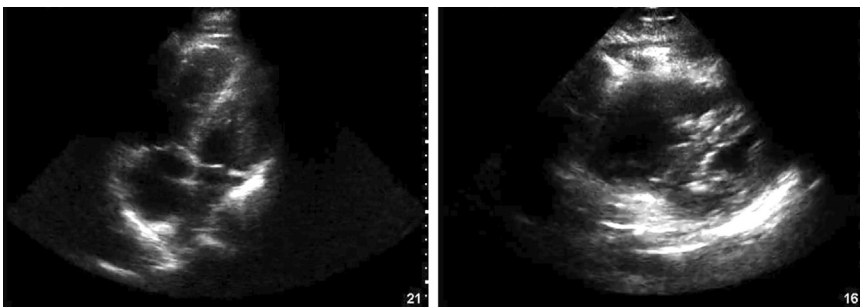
Echocardiogram demonstrating apical 4 chamber (left) and parasternal long (right) view of RV dilatation in intermediate-risk PE. (Credit to Drs. Breslin & Gurysh.)
